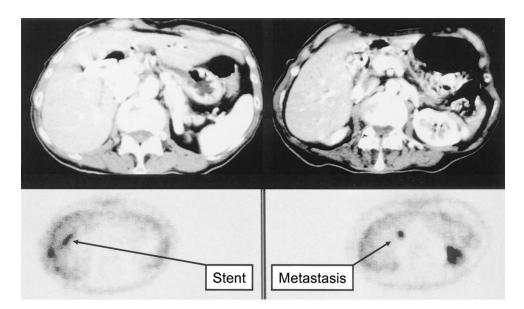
PET imaging demonstrating FDG uptake corresponding to the course of a biliary stent on the CT image indicating a benign etiology from inflammation. The true intrahepatic metastasis may be distinguished from the biliary stent when FDG-PET and CT images are interpreted in conjunction with each other.
